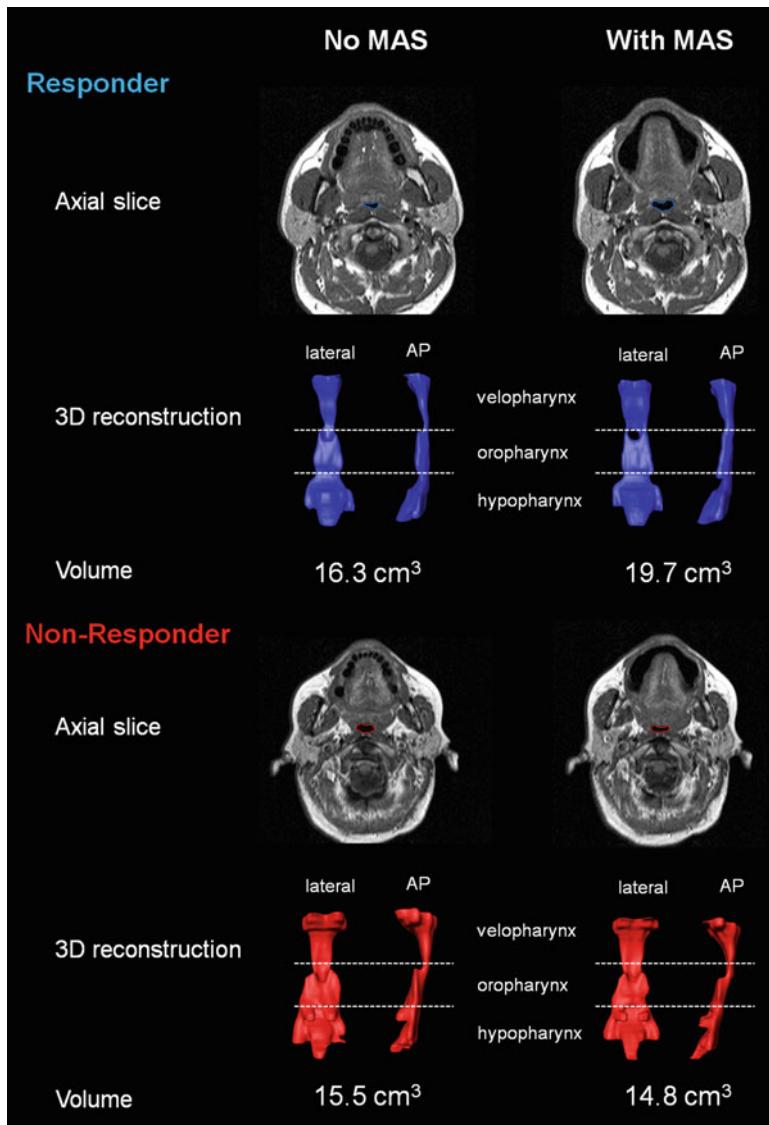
Magnetic resonance imaging comparison of the upper airway with and without MAS in a treatment responder and nonresponder. An increase in airway cross-sectional area with MAS can be seen in the axial slice of a MAS treatment responder (posttreatment AHI <5/h). The responder shows an increase in total upper airway volume with MAS compared to without MAS. The most significant changes are in velopharynx and in the lateral, rather than the anteroposterior (AP) dimension. Upper airway analysis of a nonresponder (<50% reduction in posttreatment AHI) shows no increase in upper airway dimensions and, in fact, a slight decrease in upper airway volume occurs when the MAS is in place in this particular patient
